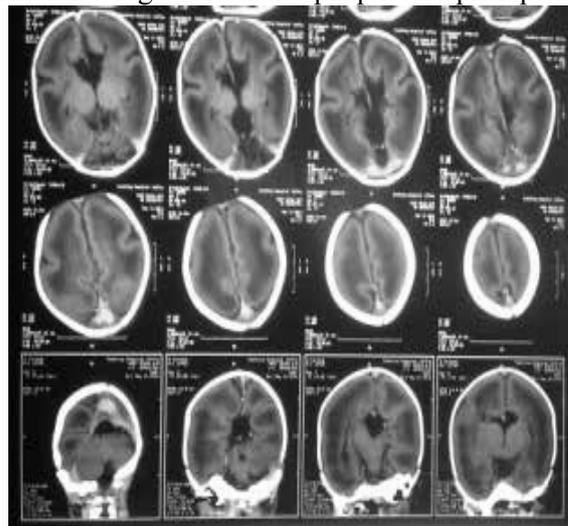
CT brain shows Corpus callosum agenesis with lissencephaly
